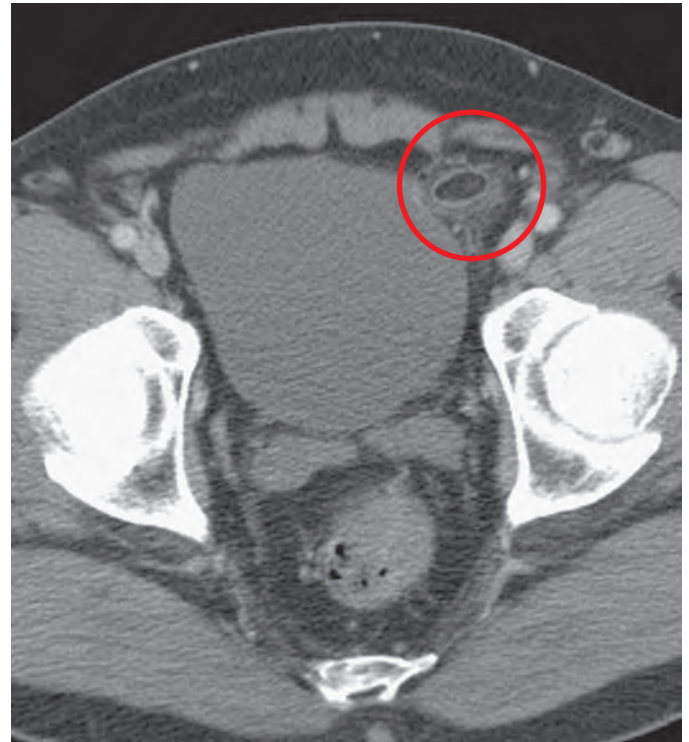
Epiploic appendagitis. CT shows an elliptical fat density structure (circle), the epiploic appendage, surrounded by increased attenuation in the pericolic fat.
